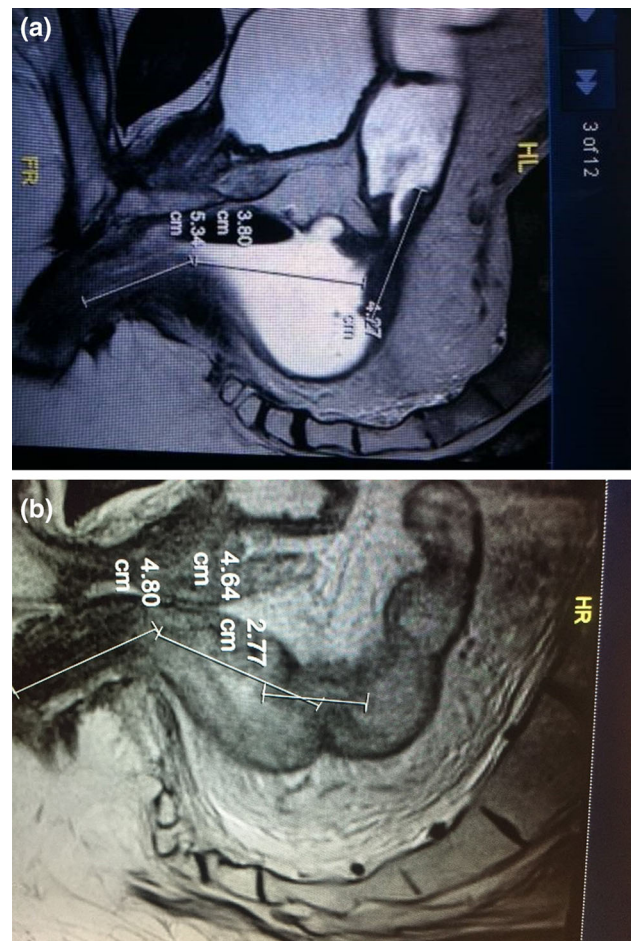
a, b Understanding the geometry of the pelvis, including the bony pelvis and the mesentery, is important in the planning phase of taTME. The surgeon must have a mind’s eye view of the pelvic and mesenteric shapes, which are patient-specific. Shown here are two different T2 weighted magnetic resonance images (mid-sagittal section) of patients with rectal carcinoma. Note the difference in the mesenteric contour and the curvature of the bony sacrum and coccyx. Examining these non-tumor related factors is important for the taTME surgeon in particular
